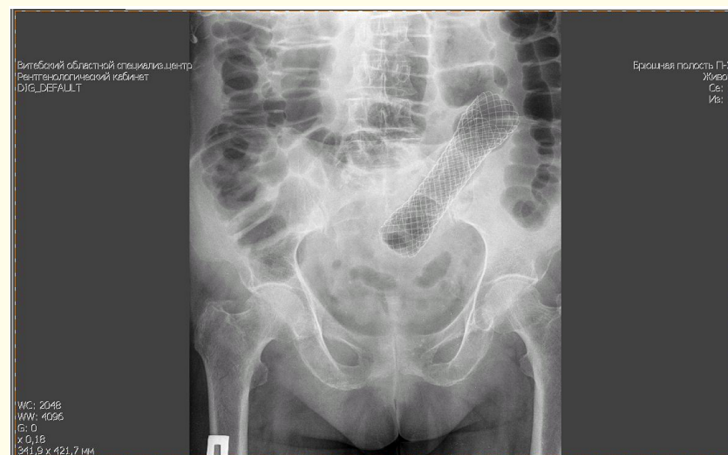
A survey radiograph of the abdominal cavity after the self-expanding stent placement into the sigmoid colon.
